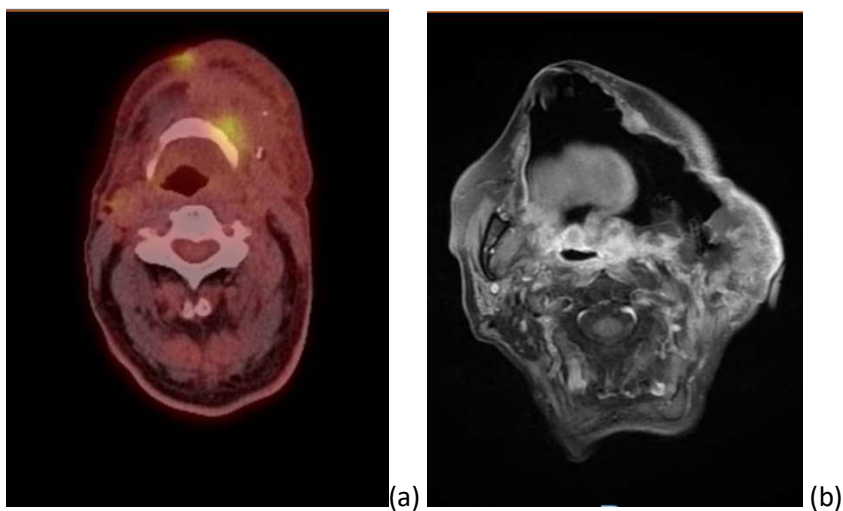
(a) Example early marginal recurrence detected on PET CT imaging with FDG avid disease evident at flap-normal tissue interface. (b) Example of advanced local recurrence demonstrated on MRI imaging where, due to the extent of disease, it is difficult to locate the original of recurrence.
